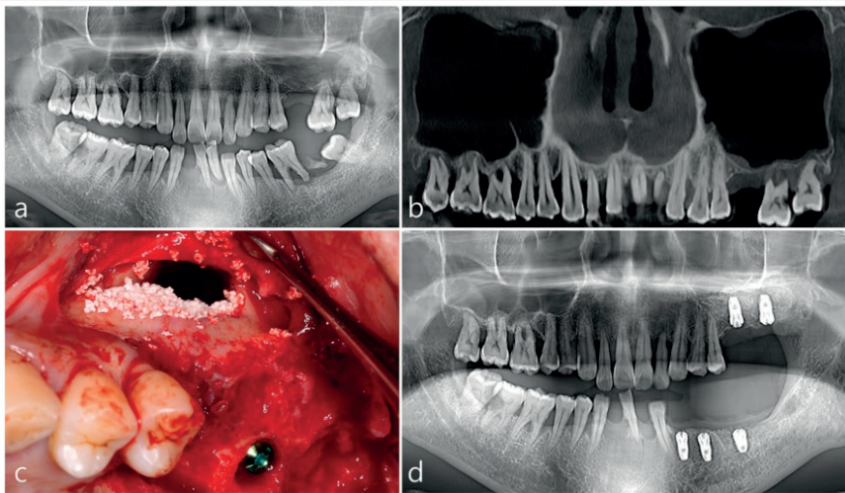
Preoperative panoramic radiograph showing severe alveolar bone loss due to advanced periodontitis (a); Panoramic view of the preoperative CBCT demonstrating no mucosal thickening in the right and left maxillary sinuses (b); Schneiderian membrane perforation occurred during sinus floor elevation (c); Grafting of the sinus cavity and opening of the superior part of the lateral window; postoperative panoramic radiograph following maxillary sinus augmentation and simultaneous dental implant placement (d). (Park, W.-B., Crasto, G. J., & Kang, P. (2022) Preliminary Approach for Open Lateral Window Technique for Successful Maxillary Sinus Augmentation in the Unreparable Wide Perforation Area of Schneiderian Membrane. *Applied Sciences*, 12(19), 9725)
